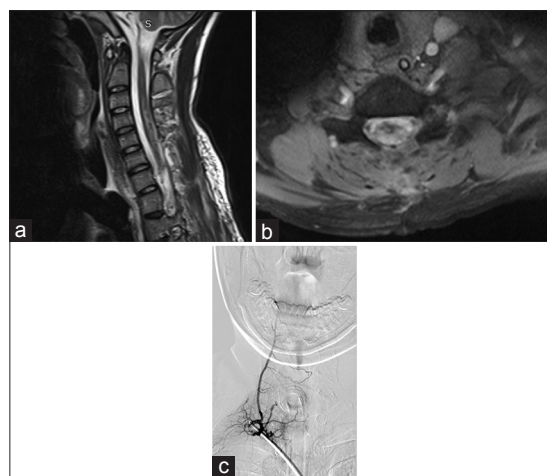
(a) Ten days postoperative sagittal MRI showing complete removal of the AVM and significant improvement of the hyperintensity in the cervical spinal cord [Figure 2]. (b) Same postoperative MRI in the axial plane at the level of C7 demonstrating no flow voids inside the spinal cord. (c) Seven weeks postoperative angiogram showing no residual AVM nidus
